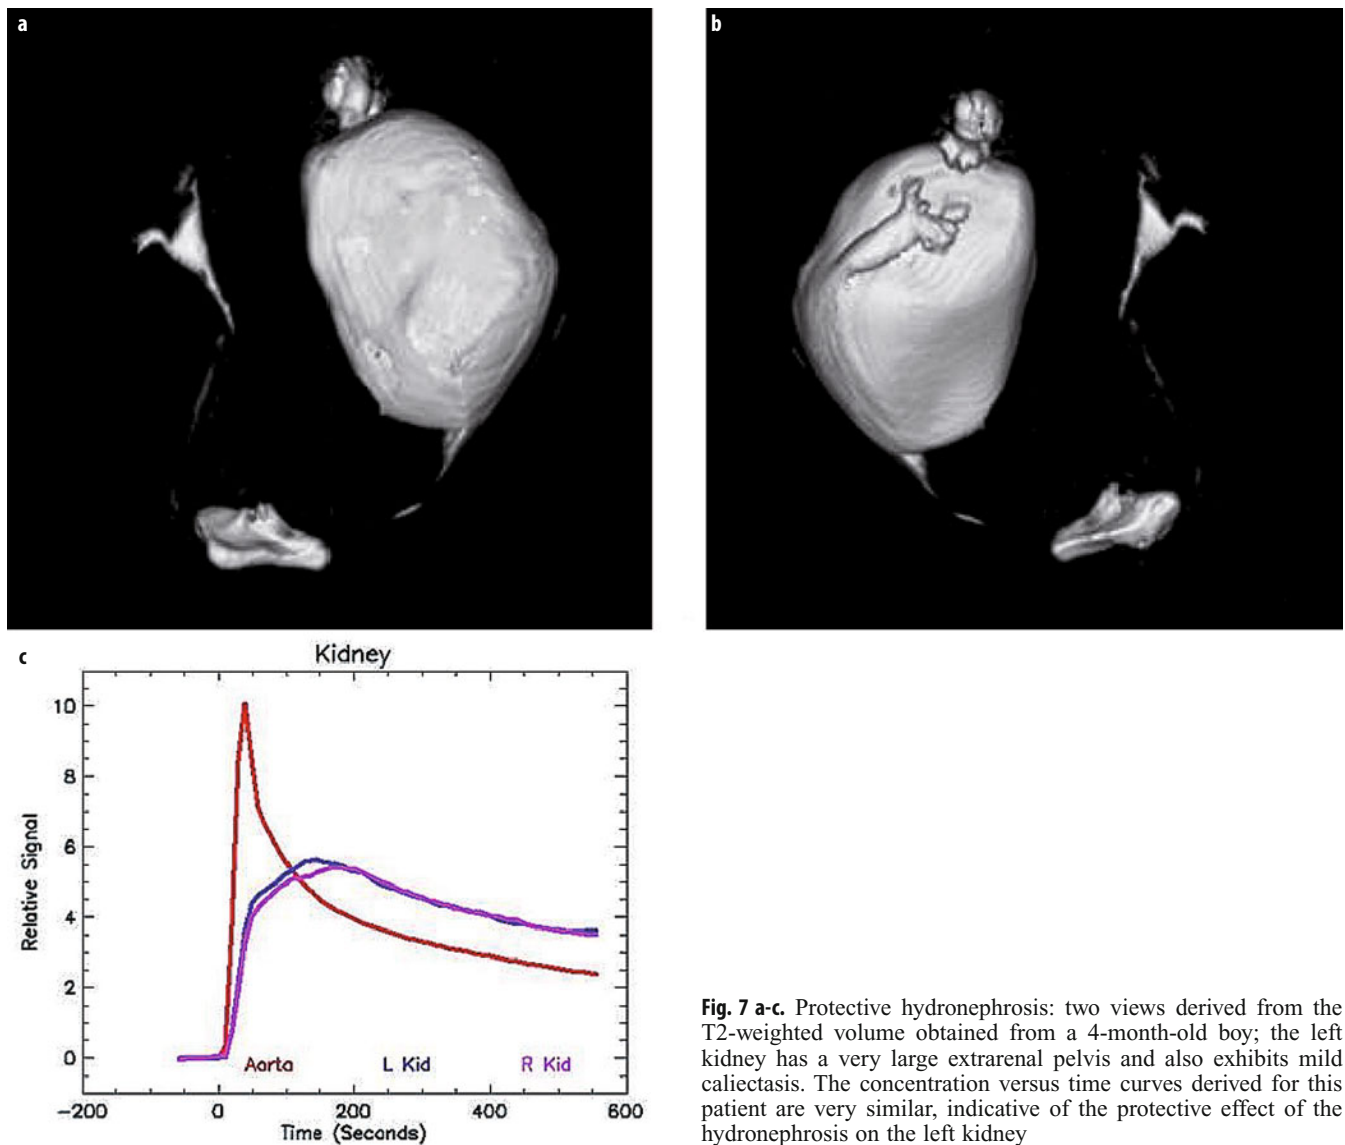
a-c. Protective hydronephrosis: two views derived from the T2-weighted volume obtained from a 4-month-old boy; the left kidney has a very large extrarenal pelvis and also exhibits mild caliectasis. The concentration versus time curves derived for this patient are very similar, indicative of the protective effect of the hydronephrosis on the left kidney
